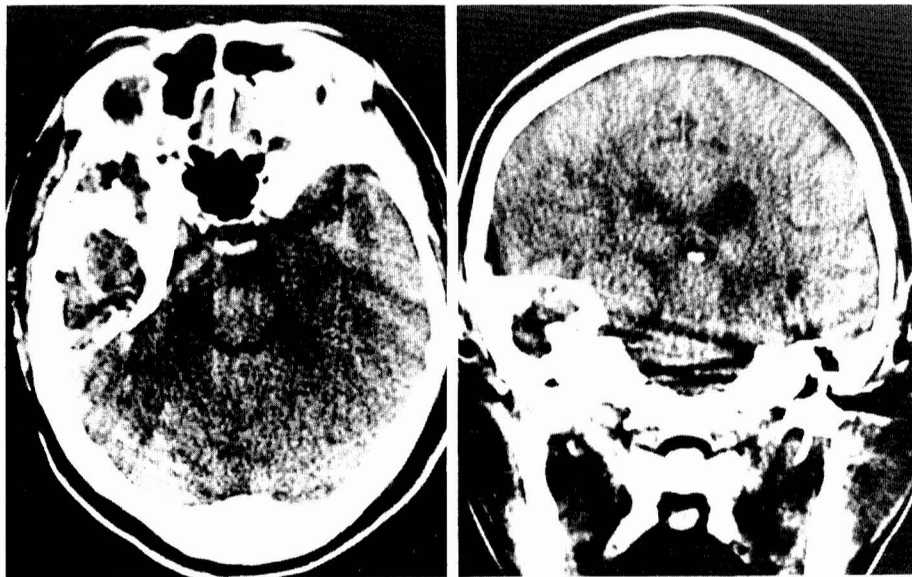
Left*, plain computed tomographic scan (axial view) showing an isodense mass within the right middle fossa and high dense portions in its marginal and central areas. *Right*, plain computed tomographic scan (coronal view) demonstrating destruction of the base of the right middle fossa.
